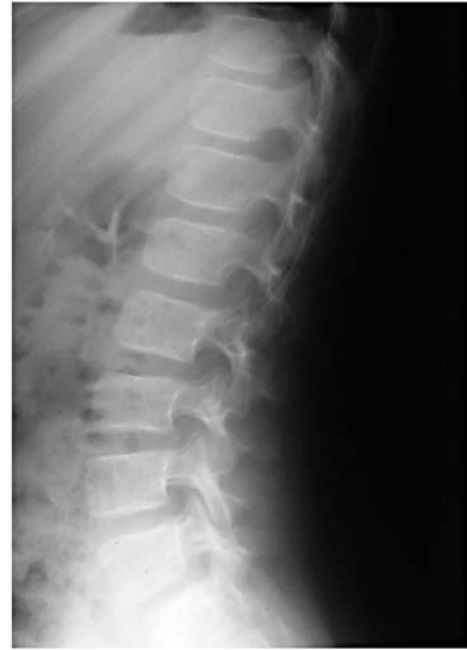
Final thoracolumbar spine radiograph reveals no residual deformity in standing position
